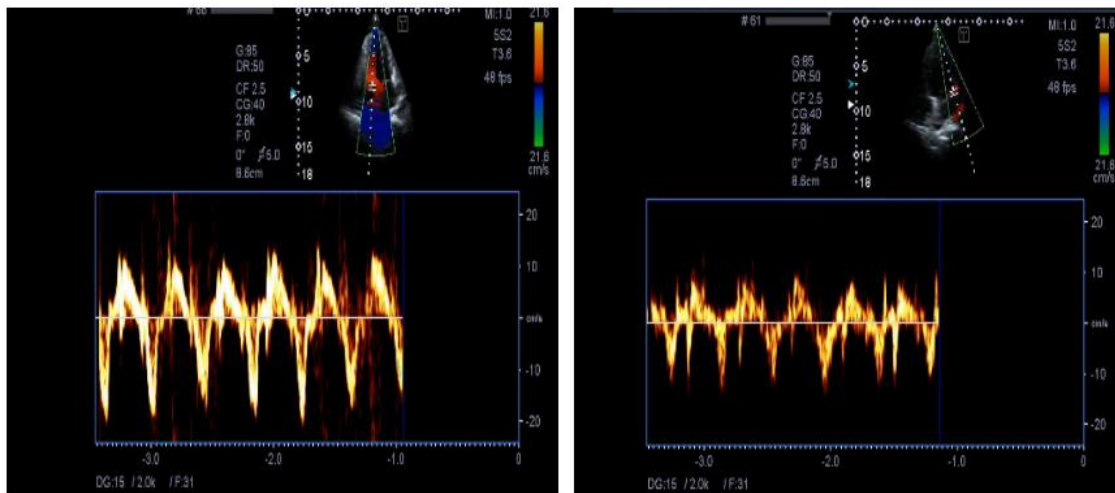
The averaged lateral e' velocity is lower than the medial e' velocity (ie, annulus reversus). Tissue Doppler imaging at the medial annulus and the lateral tricuspid annulus is presented herein.
